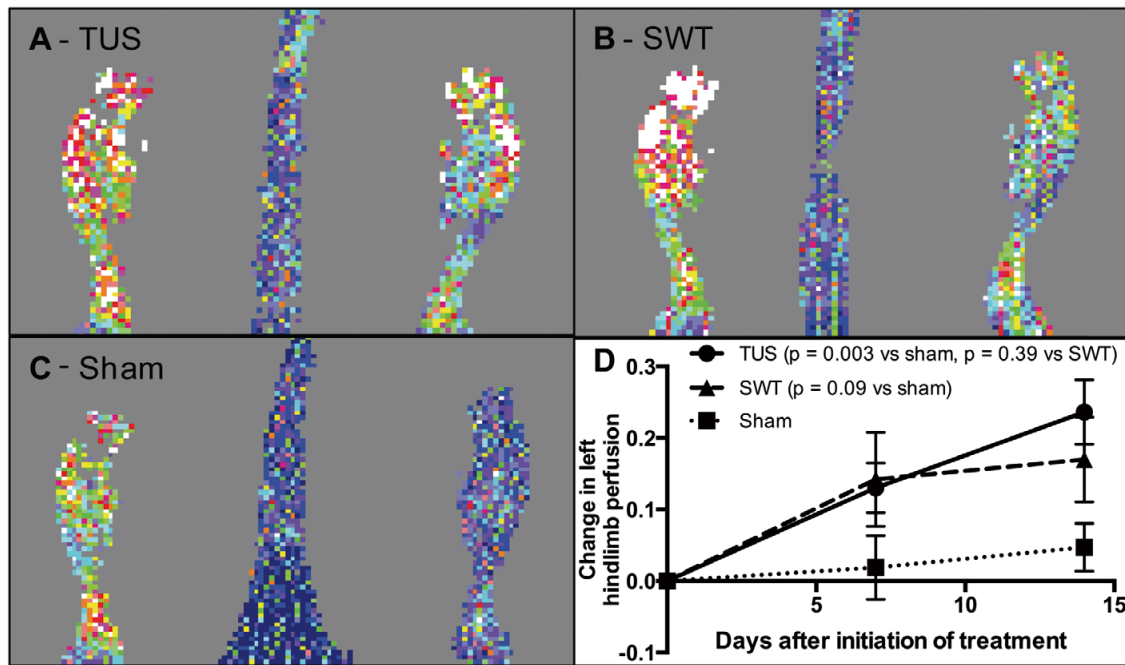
Laser Doppler scan after 2 weeks of therapeutic ultrasound (TUS) (A), shock wave therapy (SWT) (B) and sham (C) therapy. Reperfusion quantitated as change in L:R perfusion (D) over the course of 2 weeks' therapy.
